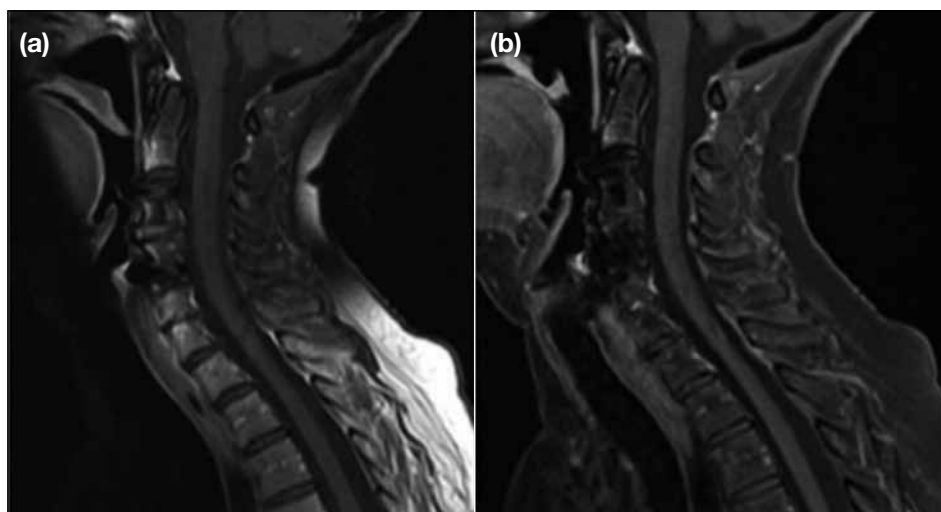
Sagittal T1-weighted images of the cervical spine using (a) conventional fat-saturation techniques that result in heterogeneous saturation of the fat in the posterior side of the neck, and (b) the Dixon technique (Siemens, Erlangen, Germany) that results in robust fat suppression and better contrast-enhanced image in the presence of metal implants (images courtesy of Siemens).
